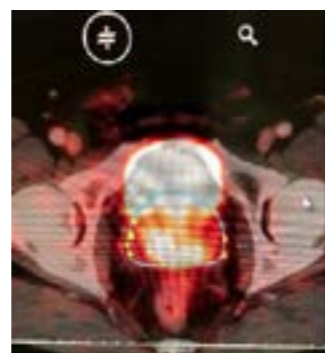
Two radiotracer uptakes on PSMA-PET/CT
